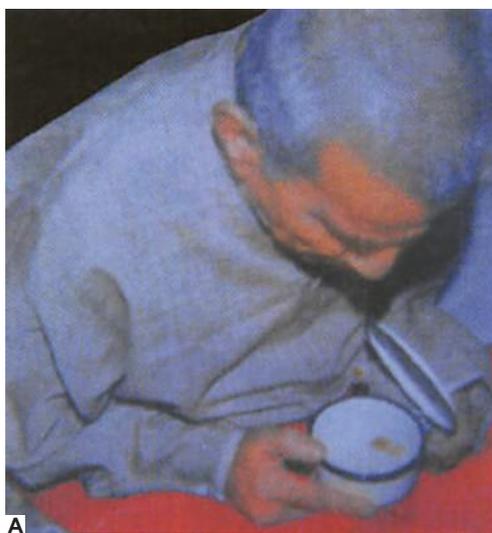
Pneumonic consolidation. A. A patient with pneumonia demonstrating hemoptysis; B. Chest X-ray showing right lower lobe consolidation (→)
